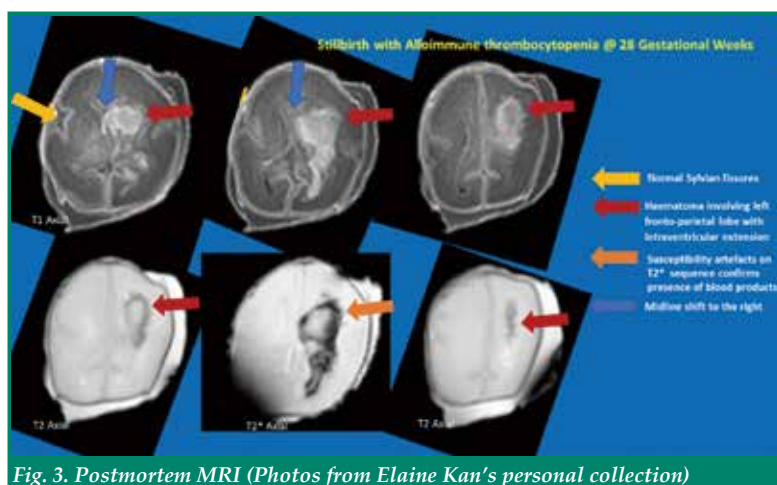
Postmortem MRI (Photos from Elaine Kan's personal collection)
